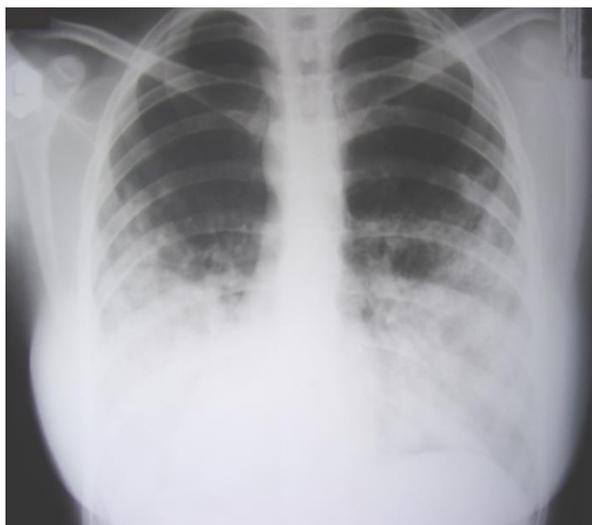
X-ray of the patient at the admission
